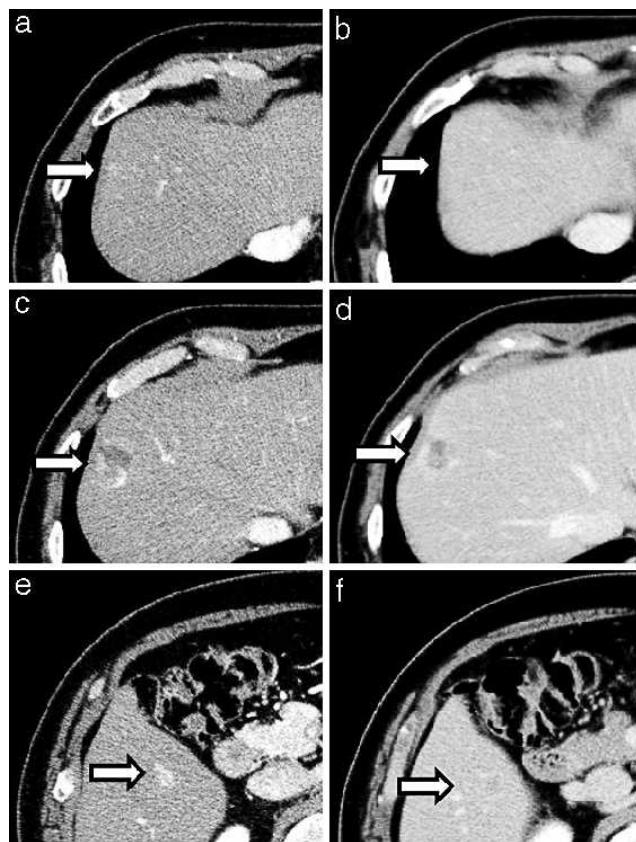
Contrast-enhanced computed tomography. Three tumors were detected, measuring 5 mm (a, b) and 20 mm (c, d) in diameter in S8, and 10 mm (e, f) in S6. Early phase (a, c, and e) and late phase (b, d, and f) findings are shown. Arrows indicate tumors.
